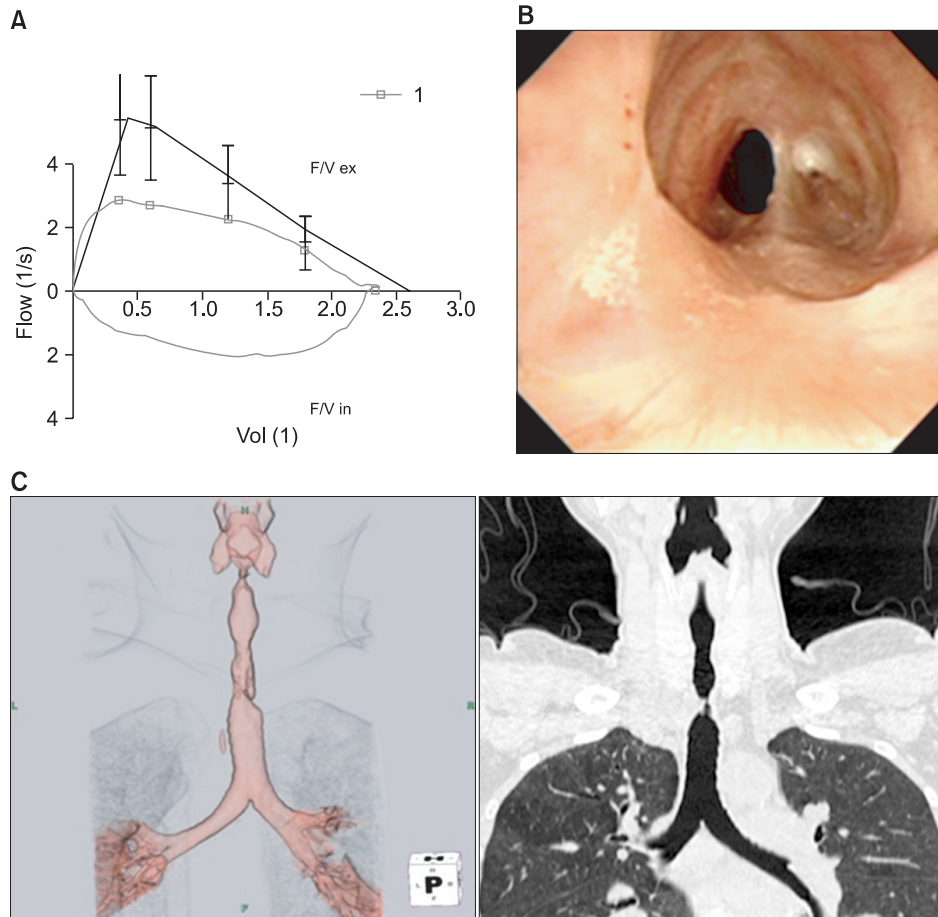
Initial pulmonary function test, bronchoscopy and chest computed tomography (CT) image. (A) Flow volume curve showed fixed obstructed pattern (forced expiratory volume in one second [FEV₁], 89.7%; FEV₁/forced vital capacity, 86.47%). (B) Bronchoscopy revealed two-thirds narrowing of upper trachea due to web-like fibrotic stenosis. (C) Chest CT showed diffuse stenosis and focal web at the cervical trachea.
